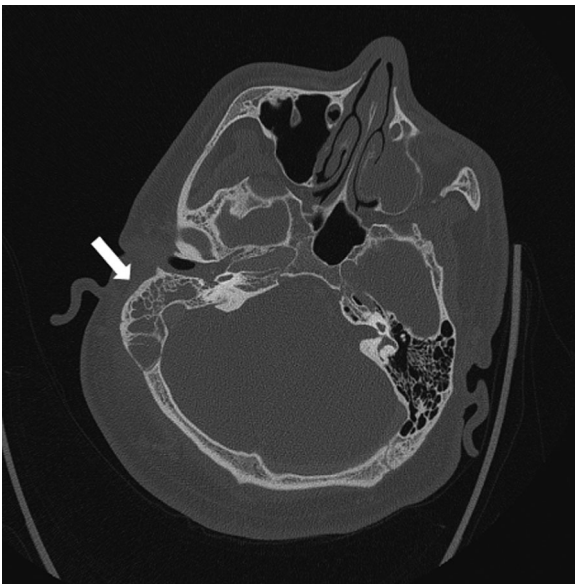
Computed tomography scan of head showing opacification of right mastoid
